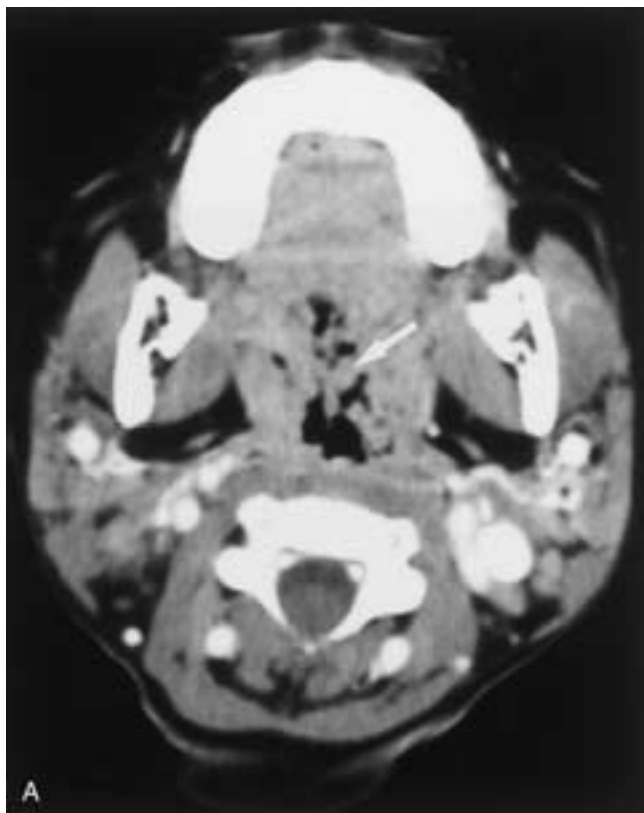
Posttransplant lymphoproliferative disorder in an immunosuppressed transplant recipient. A, Axial contrast-enhanced CT reveals frond-like enlargement of the lingual tonsils (*arrow*). B, The abnormal tissue extends into the hypopharynx and encroaches on the airway.
